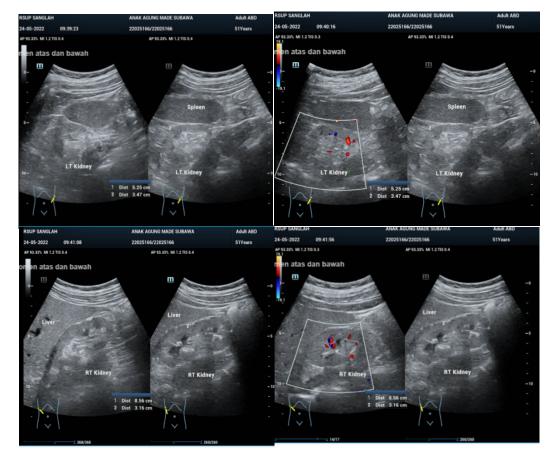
Upper Lower Abdominal Ultrasound
